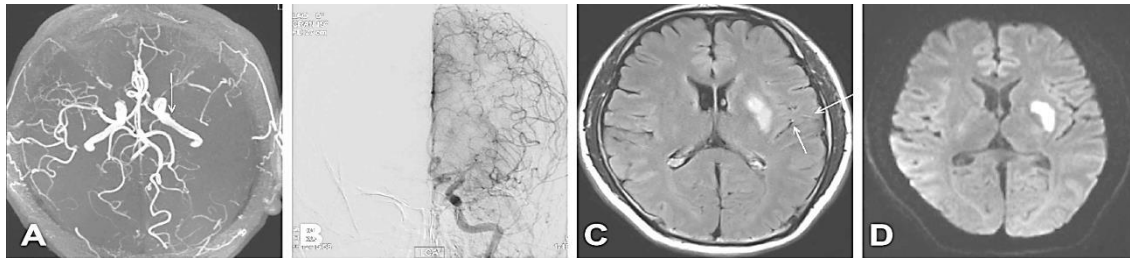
A male patient (45 years old) right limb movement disturbance for one day. A: arrow denotes M1 occlusion on MRA maximum intensity projection (MIP) images. B: scarcely any collateral vessel can be seen from angiography. C: FLAIR shows absent HV. Irregular p-WMHs score 3 and punctate foci d-WMHs score 1. D: acute stroke ASPECT score is 2.
